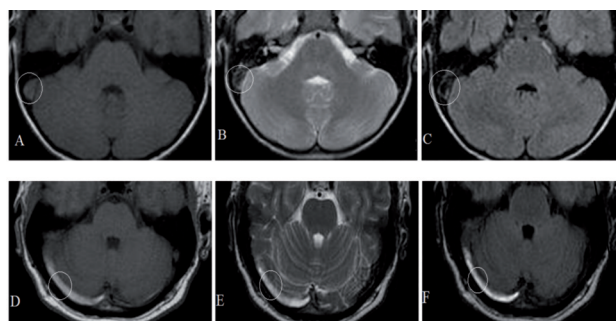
Axial T1-weighted (A-isointense), axial T2-weighted (B-hypointense) and axial-flare (C) MRI show acute thrombus of transverse sinus. Axial T1-weighted (D-isointense), axial T2-weighted (E-hypointense), and axial-flare (F) MRI show subacute thrombus of transverse sinus at the same patient (no. 7 for Tables 1, 2, and 3).
